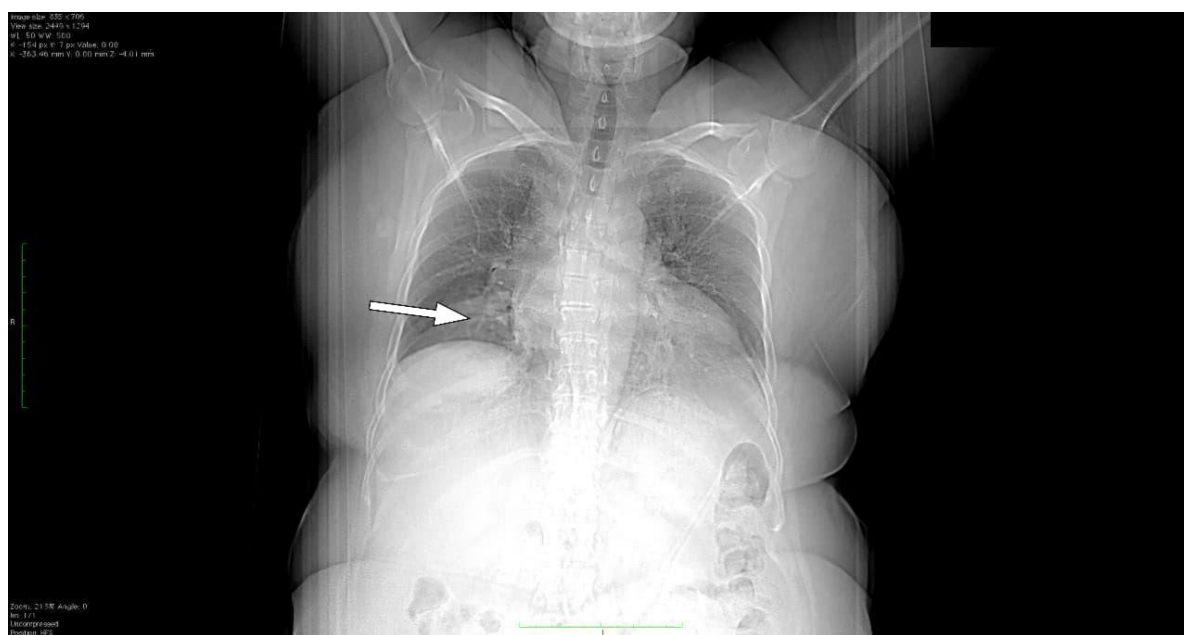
CT scout/scannogram demonstrating a subtle right lower-zone pleural/parenchymal radio-opacity (arrow), which was subsequently characterized as a large pleural-based mass-like consolidation on computed tomography.
